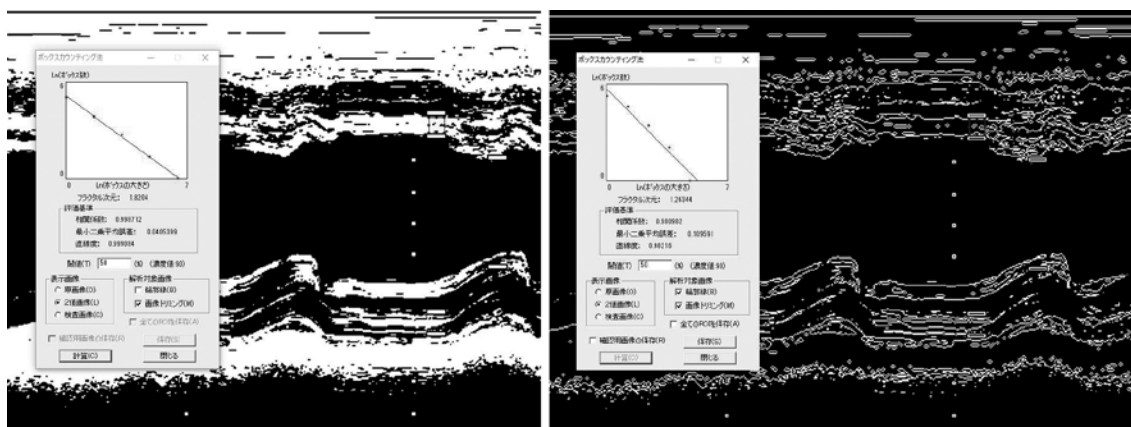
Images depicting the implementation method of fractal analysis using echocardiographic still images (left: mass mode, right: outline mode). The region of interest was drawn using the contours of the ventricular septum and posterior wall as boundaries, extracted using motion (M)-mode. Mass mode is defined as the maximum value obtained by setting the density threshold. Outline mode emphasizes the outline of the object by analyzing the complexity of the real outline.
